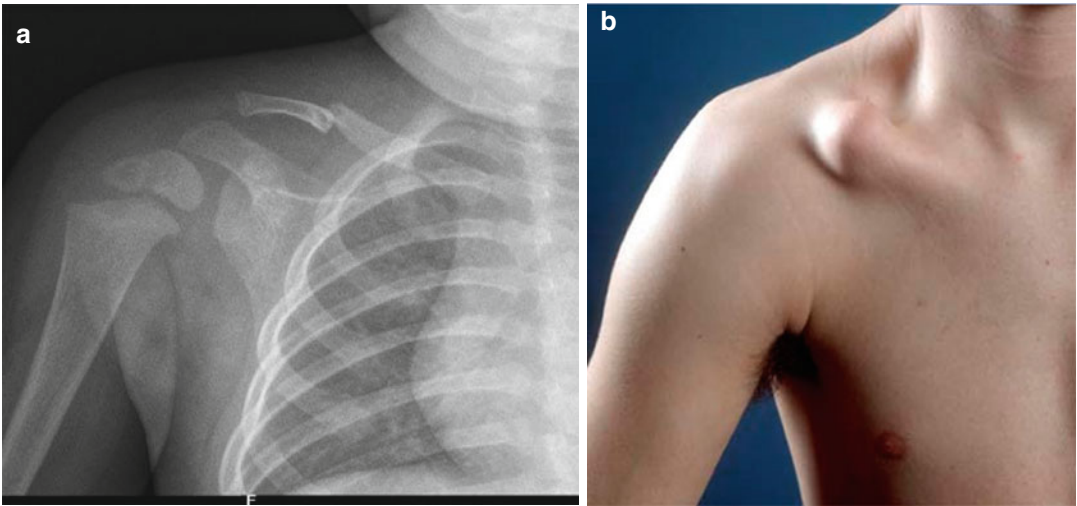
Radiograph of a child with a congenital pseudarthrosis of the right clavicle (a) and the clinical appearance in an older child who did not have any treatment (b)
